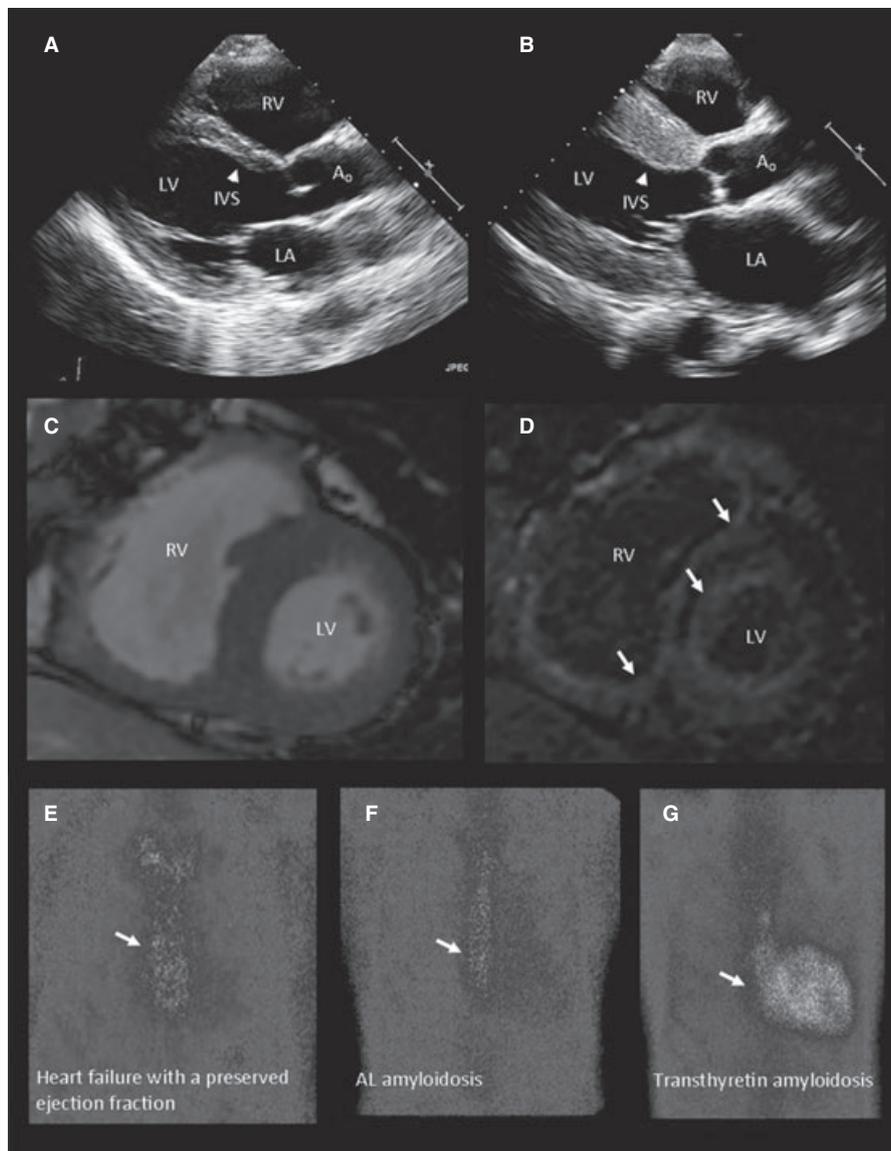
Characteristic imaging findings in patients with cardiac transthyretin amyloidosis. (A) Echocardiogram in individual without cardiac disease. Interventricular septum (IVS) (arrowhead) is normal in thickness. (B) Echocardiogram in individual with familial amyloidotic cardiomyopathy due to Val122Ile mutation demonstrates markedly thickened IVS. (C) Cardiac magnetic resonance imaging scan in individual with transthyretin amyloidosis showing short axis of heart. (D) Identical short axis view from the same individual demonstrates diffuse subendocardial enhancement of both ventricles characteristic of amyloid deposition. Differences in cardiac retention of a technetium-pyrophosphate-99 radiotracer in individuals with heart failure and a preserved ejection fraction in hypertension (E) and AL amyloid (F) demonstrating no cardiac tracer retention compared with the individual with cardiac transthyretin amyloidosis (G). LA = left atrium; LV = left ventricle; RV = right ventricle; Ao = aorta.
